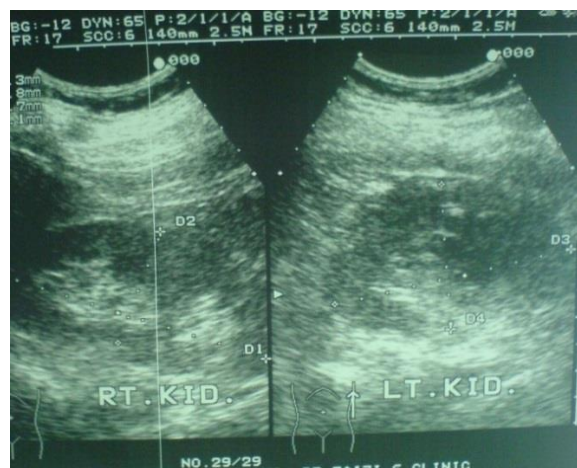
Ultrasonography showed 7×8 cm heterogenic solid mass with clear wall and central necrosis at middle- lower pole of right kidney.
